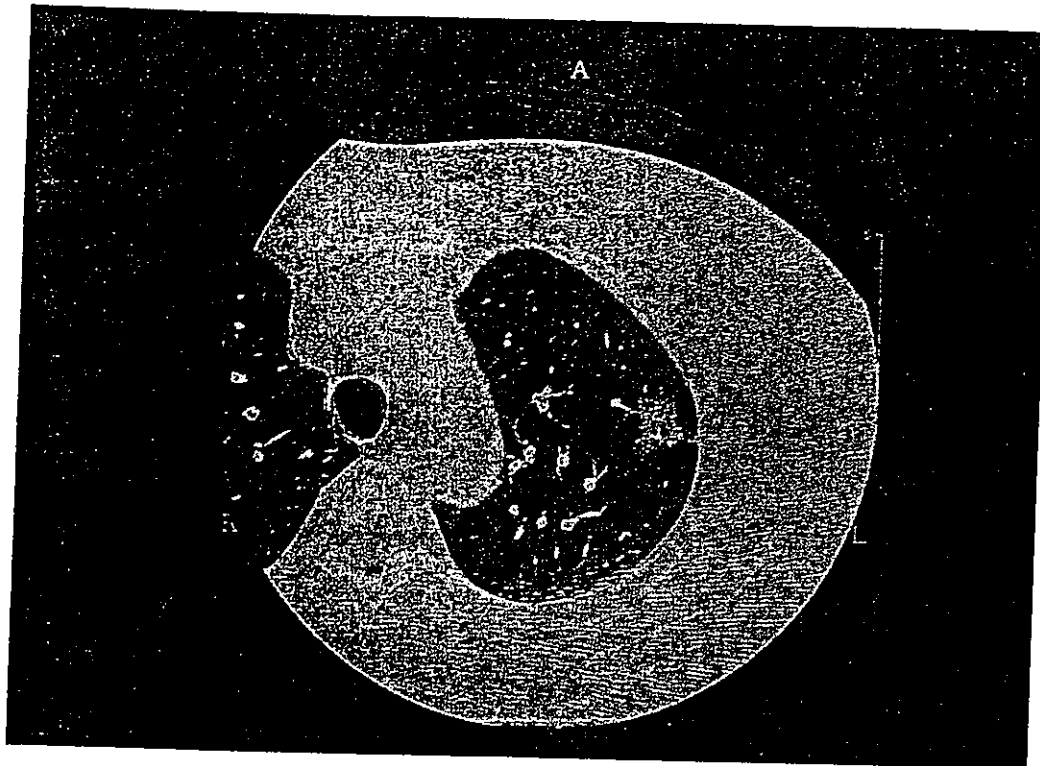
Representative findings of high-resolution computed tomography (CT) showing a non-pure ground-glass opacity (non-PGGO) tumors. A solid component can be seen at the center of the tumor.
